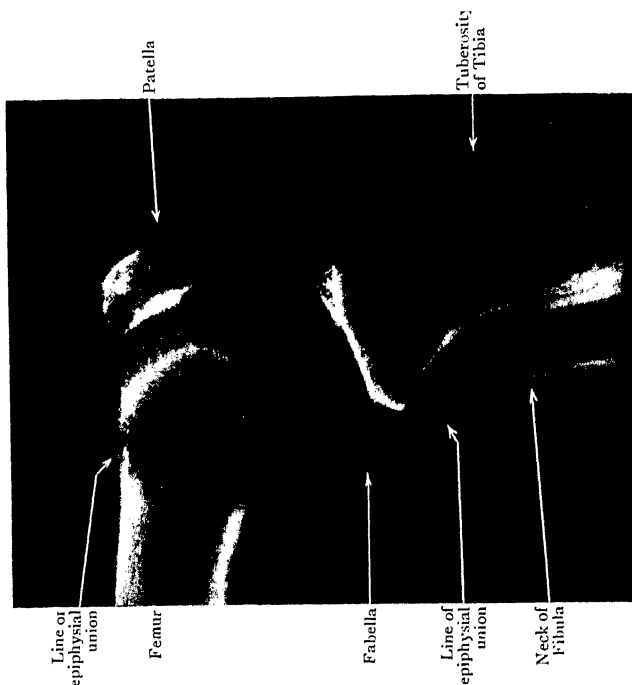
Lateral Radiograph of the same Knee, semi-flexed. Note the change in the areas of contact of the Femur with the Patella and Tibia.
